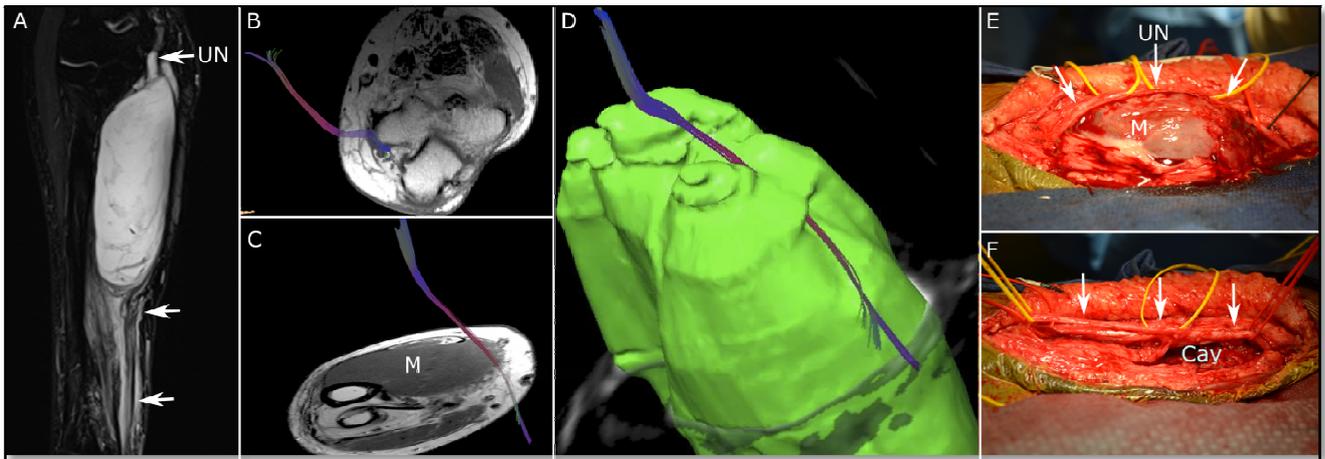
Ulnar nerve myxoid neurofibroma. Sagittal STIR image (A) showing a large T2 hyperintense mass along the course of the ulnar nerve (UN, arrows). Tractography superimposed on T1-weighted images (B and C) demonstrates the ulnar nerve to be predominantly along the superficial aspect of the mass (M), which is better appreciated with 3D reconstruction (D) of the tumor (green) and the ulnar nerve (blue and purple fibers). Surgical photograph (E) confirms that the majority of the ulnar nerve (UN, arrows) is superficial to the mass (M). Following resection (F), the ulnar nerve (arrows) remains intact, shown lifted above the resection cavity (Cav).
